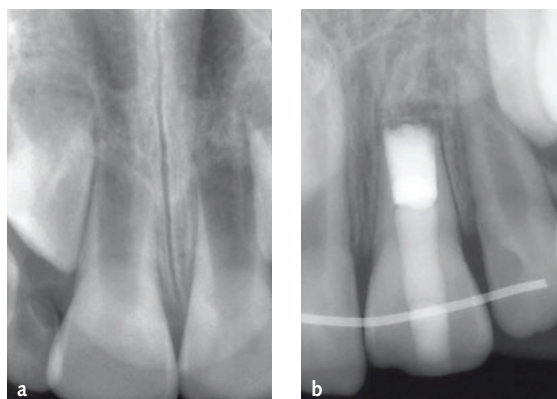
a) Preoperative radiograph of tooth 21 presenting with pulp necrosis and apical periodontitis after dental trauma. b) Radiographic control 2.5 years after root canal treatment with a persistent apical lesion. Treatment of this tooth was not considered successful.
